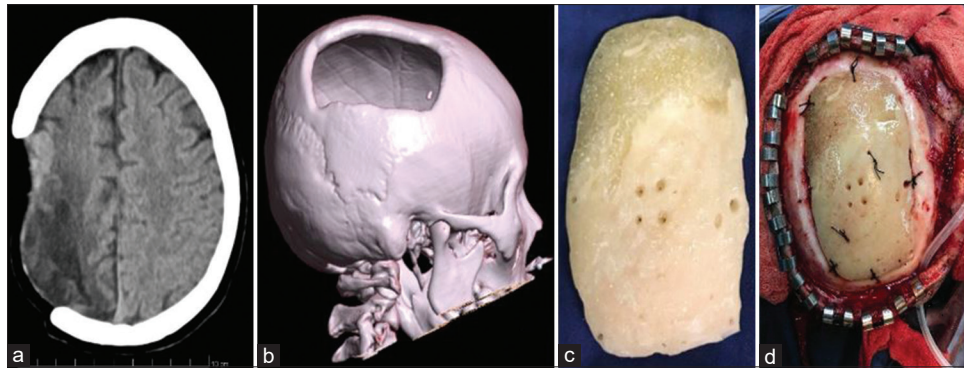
Preoperative computed tomography (a) showing cranial defect with three-dimensional printed (b) bone cement prosthesis (c) and well fitted intraoperatively (d)
